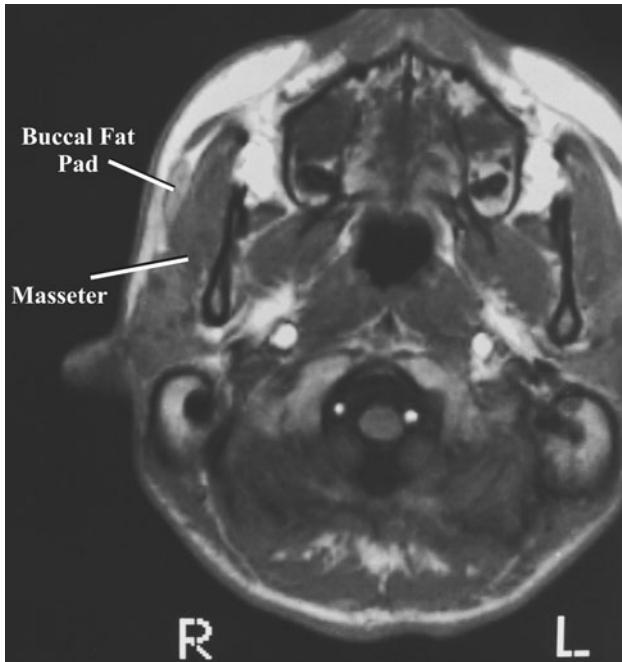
Cross section of T2 MRI at the level of the oral cavity and the hard palate. The BFP is evident anteriorly to the masseter
